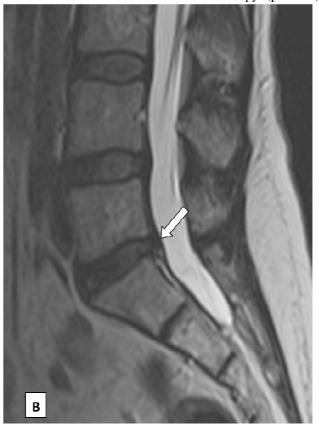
SAGITTAL T2WI MRI OF A PATIENT BEFORE (A) AND AFTER (B) TREATMENT. THE MORPHOLOGY GRADING CHANGED FROM GRADE 2 (PROLAPSE) TO GRADE 1 (PROTRUSION).
